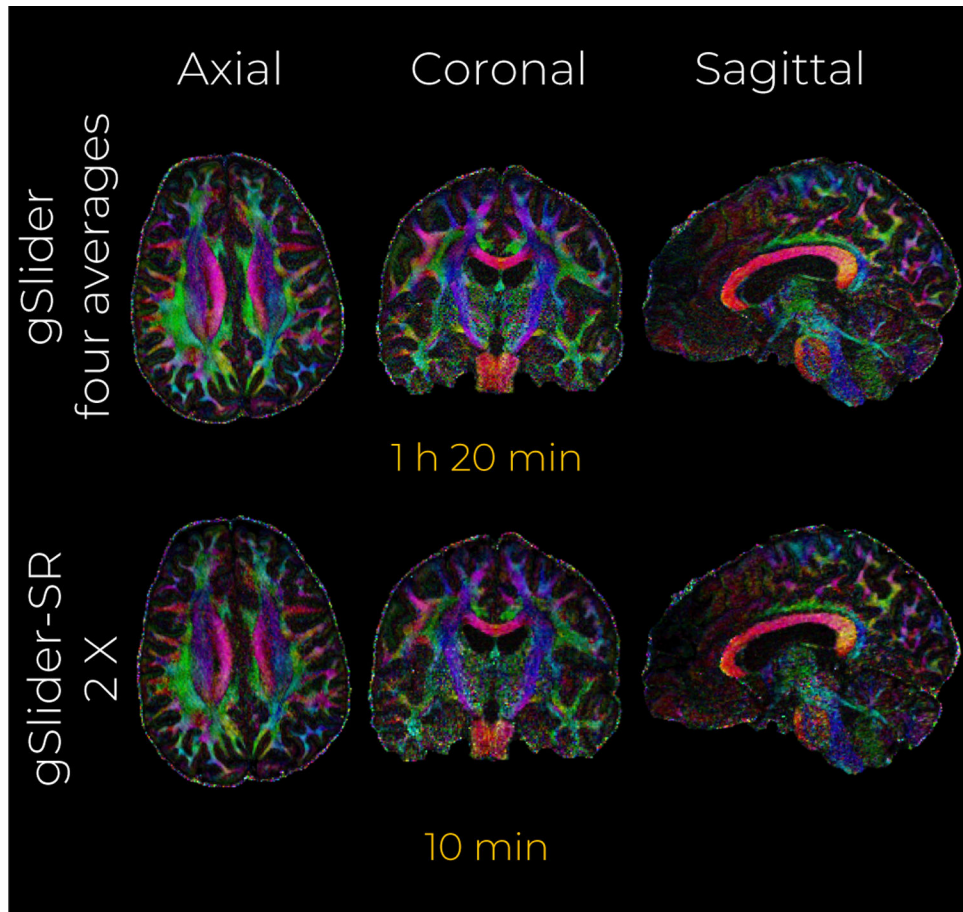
In-vivo data experiment with an acceleration factor of 2 X. A middle axial, coronal and sagittal slice of the color-encoded FA maps estimated from the reconstructed DWI volumes with gSlider (four averages) and gSlider-SR are shown.
